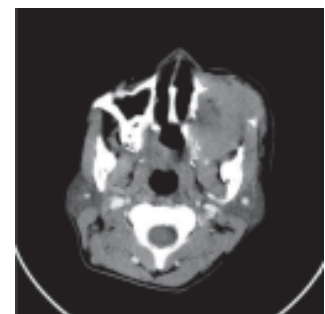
CT scan showing disease in left maxilla, extending to the infratemporal fossa and anteriorly to the soft tissues of the cheek
